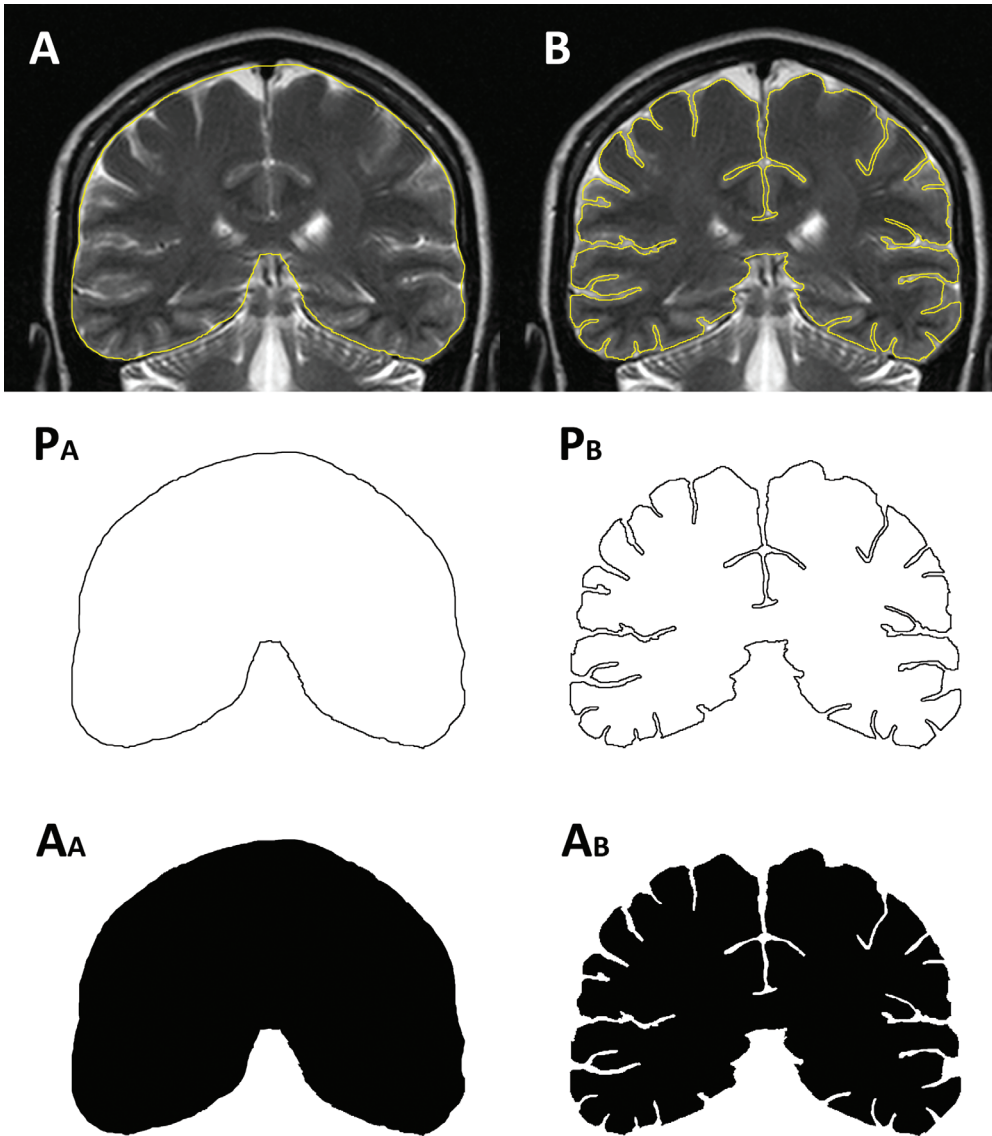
MRI brain scan of 32 years old female individual, 3rd coronal section. Euclidean geometry based morphometry of cerebral hemispheres: determining area (A_A and A_B) and perimeter (P_A and P_B) values
